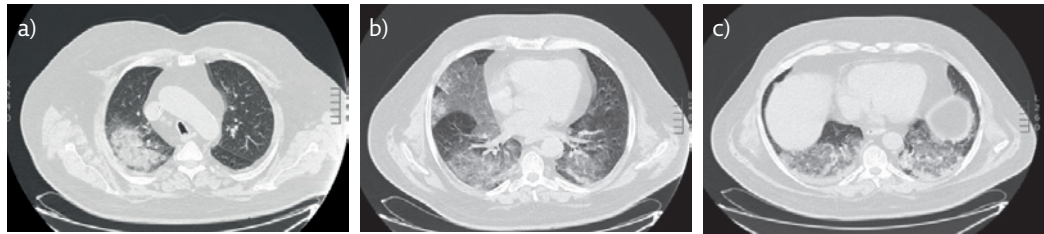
a-c) CT scan of the chest demonstrating multiple confluent areas of parenchymal consolidation associated with ground-glass opacities in both lower lobes, medium lobe and in the posterior segment of the right upper lobe.
